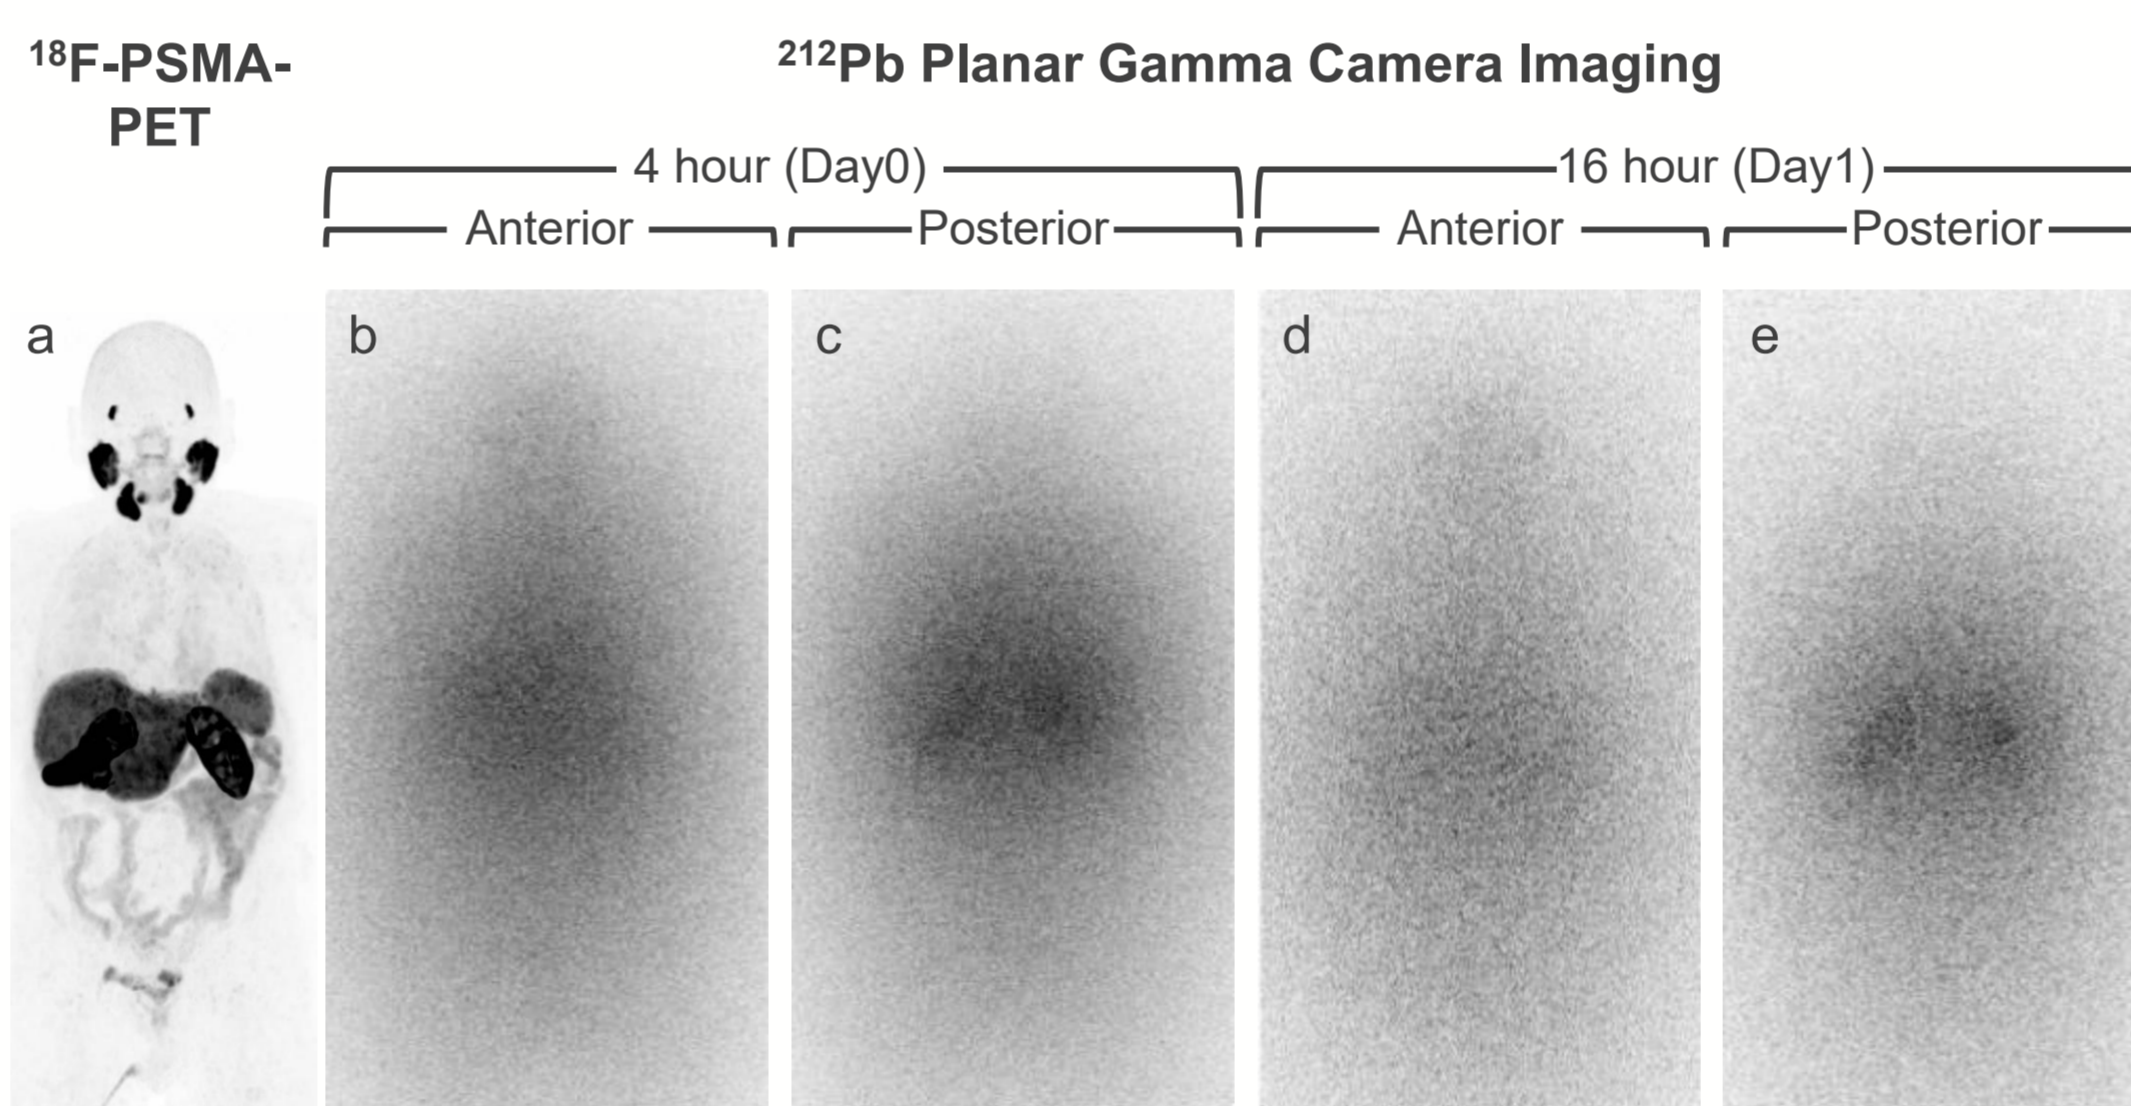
Baseline ¹⁸F-PSMA-PET (a) as reference for planar gamma camera imaging post-administration of AB001 for Patient ID01 (b-e). MIP (scaling 0-20) and WB summed (scaling 0-max).
